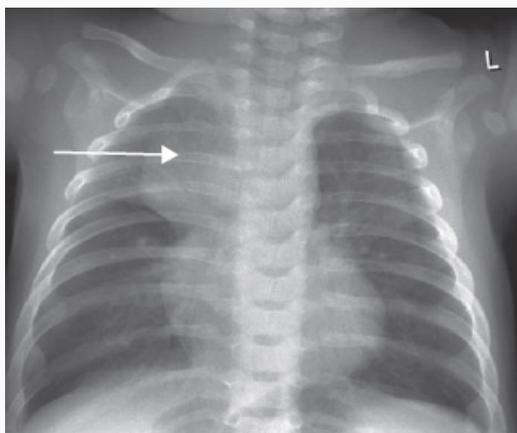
Chest radiograph showing right upper lobe collapse in a child (white arrow).
